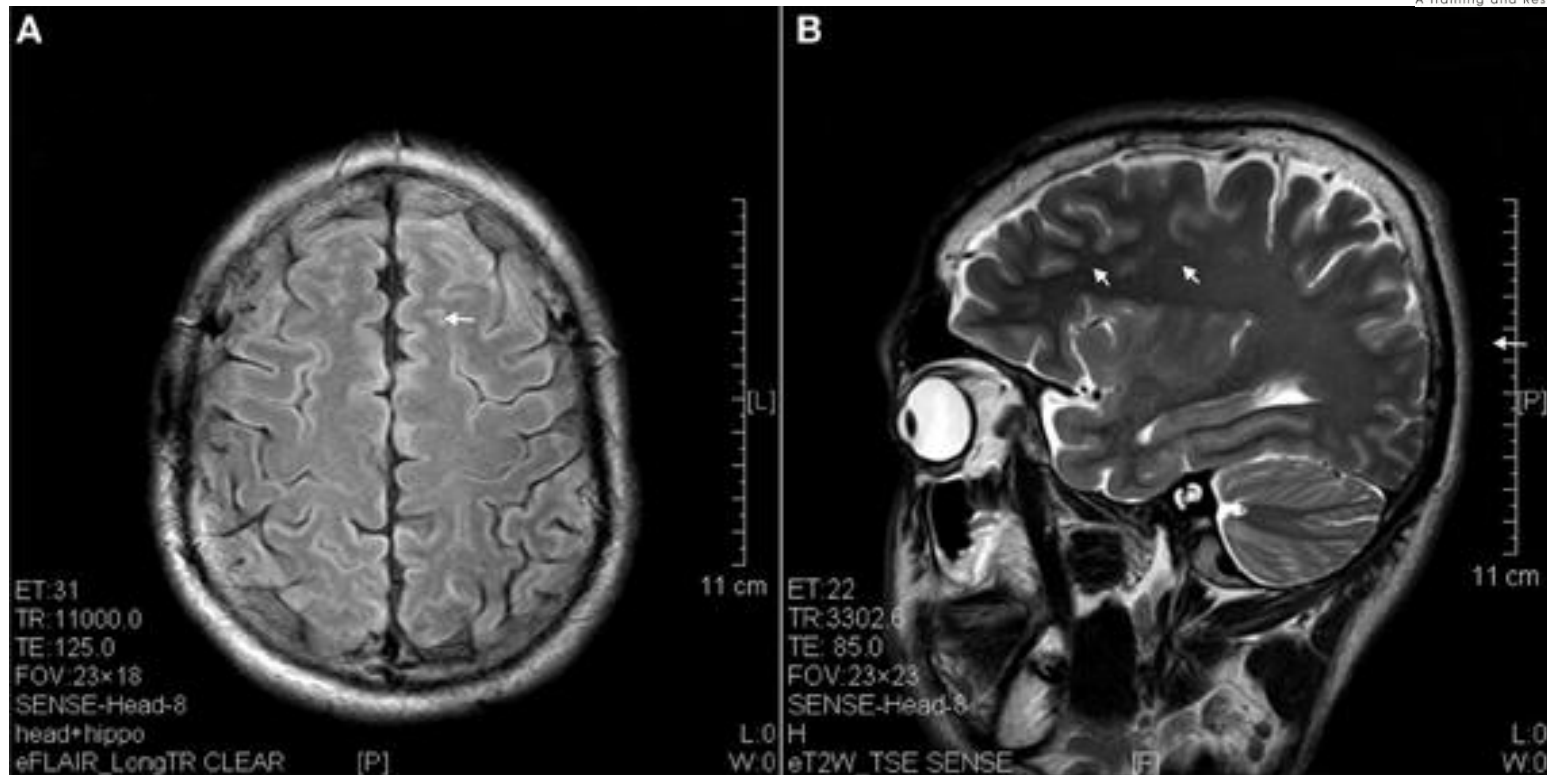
Hyperintense spots (arrow) in superficial white matter and internal capsule of ketamine addicts. (A) FLAIR imaging of a 1 year ketamine addict. (B) T2 imaging of a 3 years ketamine addict.
